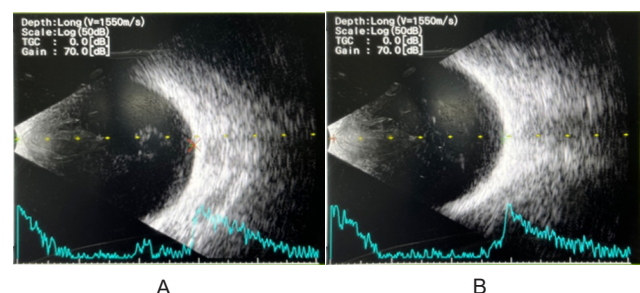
Eye ultrasound of the second patient's (A) RE and (B) LE.
